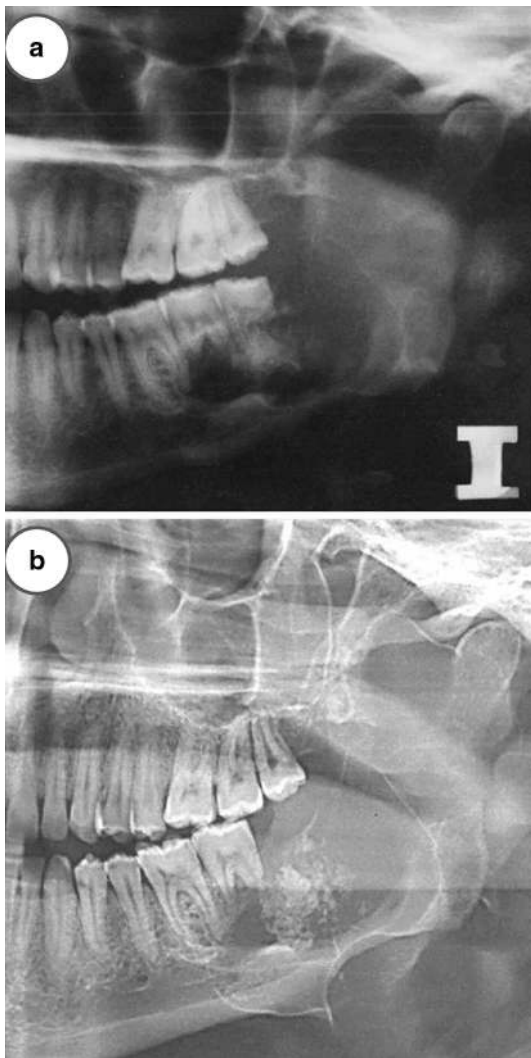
Case 2. a A well-defined, multilocular radiolucency with a central focus of radiopacity extending from the *left lower* first molar up to the midportion of ascending ramus. Note root resorption of second and third molars. b A panoramic radiograph taken 3 months later demonstrates an increase in size with marked buccal expansion
